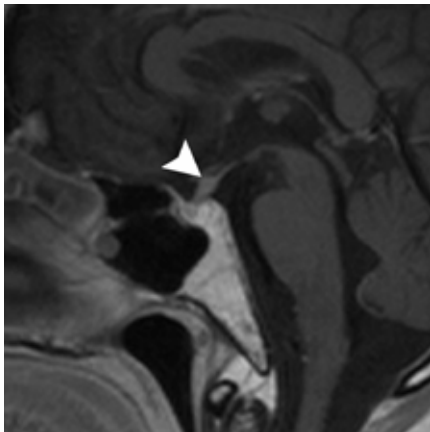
IgG4-related hypophysitis: On a sagittal contrast-enhanced T1-weighted MR image, thickening of the pituitary stalk is evidenced (arrowhead).
